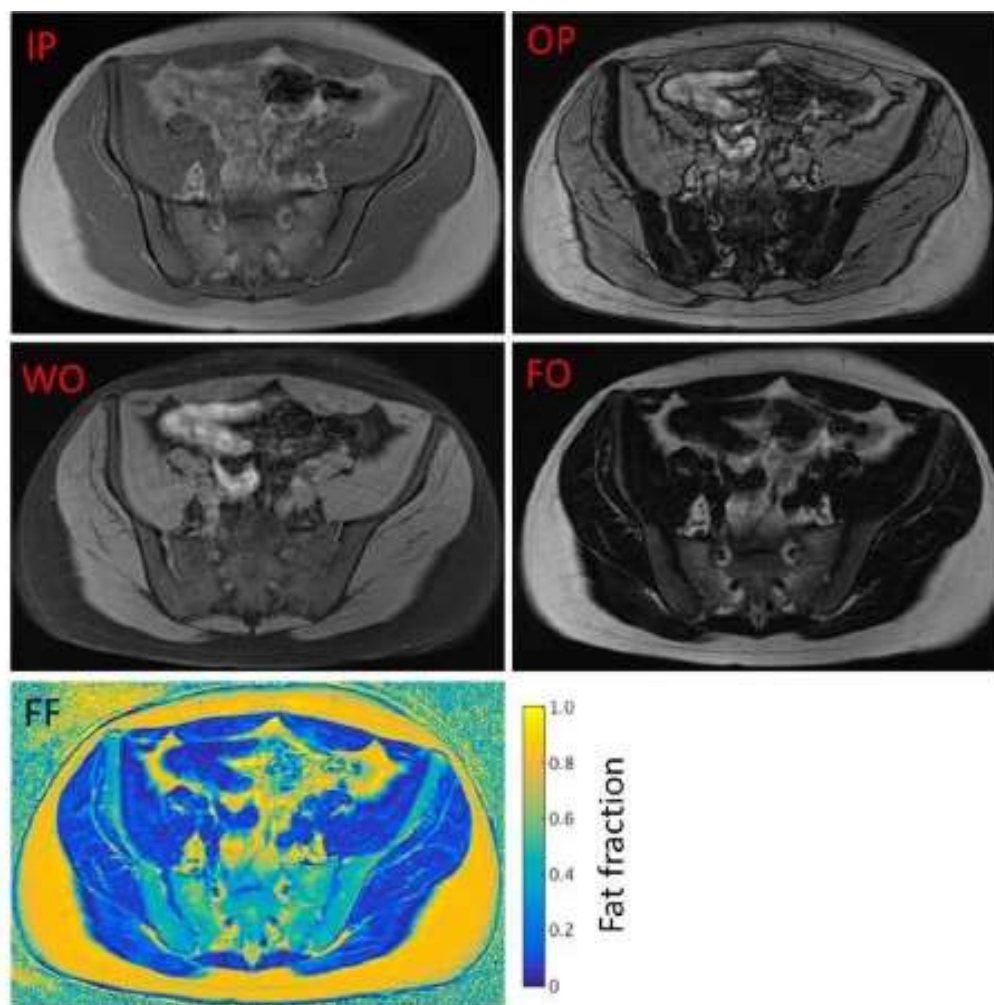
Representative case of 49/M showing CSE-MR images. Images are acquired at IP and OP TE_s. Addition and subtraction of these images produces water only (WO) and fat only (FO) images, respectively. Fat fraction (FF) maps is then generated from the WO and FO images as shown above.
